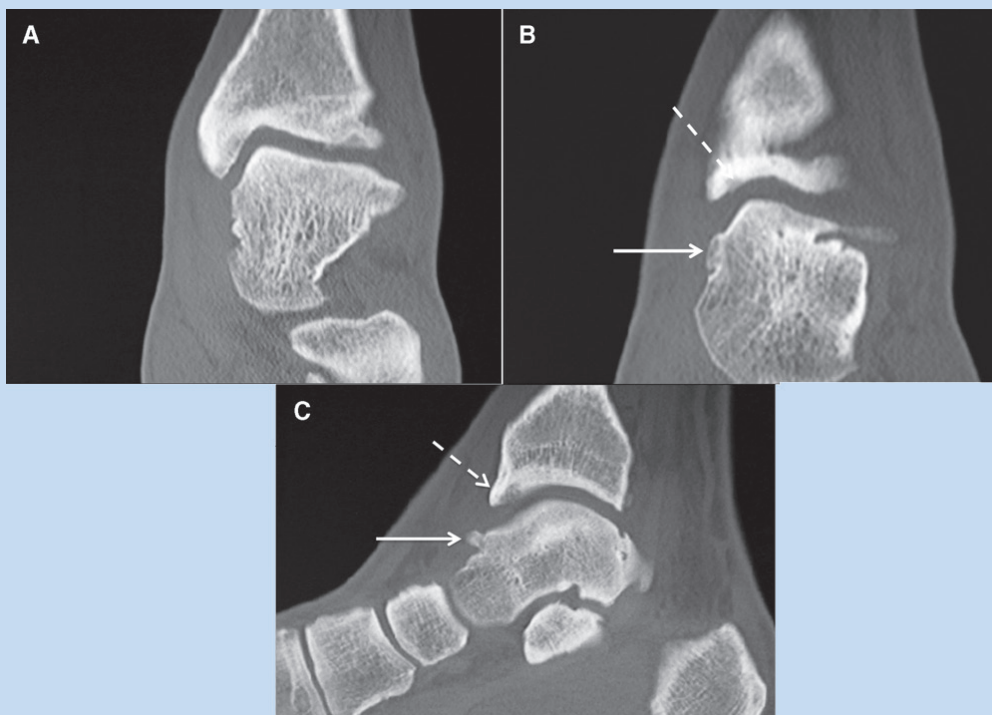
A, semicoronal computed tomography section through the anterior ankle joint in a male basketball player. The medial ankle mortise contour is normal in this section. B, computed tomography section anterior to the section in A, through the tibial impingement spur (broken arrow). The spur changes the apparent contour of the ankle joint medially compared to A. A portion of the talar spur is also seen (solid arrow). C, sagittal computed tomography reconstruction of the patient in A and B. The “kissing” tibial spur (broken arrow) actually extends and hangs downward, like an awning, in front of the normal anterior tibial contour. A talar spur is also seen (solid arrow).
